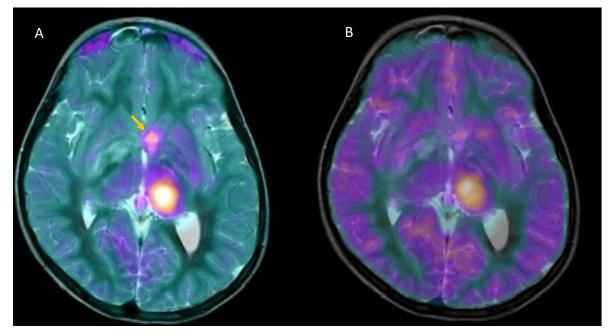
Comparison between <sup>11</sup>C-Methionine PET/MRI (A) and 18F-Fluodeoxyglucose PET/MRI (B) in a patient with highgrade glioma. Notice the low normal brain tissue uptake of <sup>11</sup>C-Methionine compared to <sup>18</sup>F-FDG, which allowed identifing a further spot of focal uptake in the right anterior commissure (arrow).
